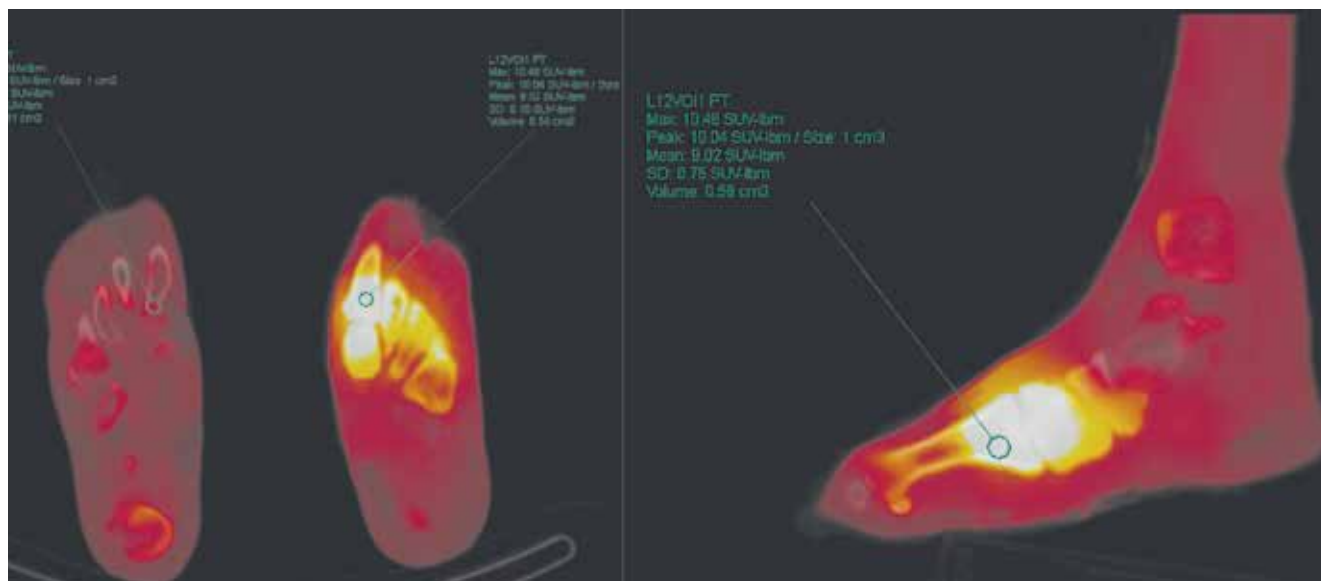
Patient N., type II diabetes mellitus – osteomyelitis case: SPECT/CT images in axial and sagittal planes demonstrating intense radiopharmaceutical hyperfixation (SUVlbm (max) = 10.48) in medial cuneiform, base of first metatarsal, intermediate cuneiform, base of second metatarsal, stumps of third and fourth metatarsals, and base of fifth metatarsal – with signs consistent with marginal lytic lesion (septic lesion)
